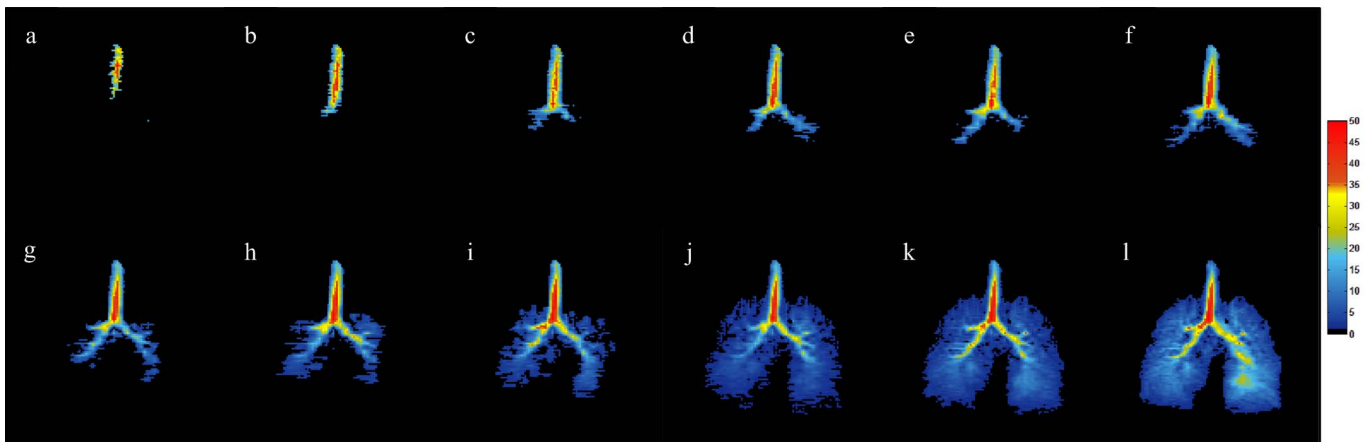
For a healthy volunteer, twelve representative frames of *in vivo* HP  $^{129}\text{Xe}$  dynamic MR images are achieved using the proposed HUP method. (a-l) The 3<sup>rd</sup>, 6<sup>th</sup>, 9<sup>th</sup>, 12<sup>th</sup>, 15<sup>th</sup>, 18<sup>th</sup>, 21<sup>st</sup>, 23<sup>rd</sup>, 25<sup>th</sup>, 27<sup>th</sup>, 29<sup>th</sup>, and 31<sup>st</sup> frames.
